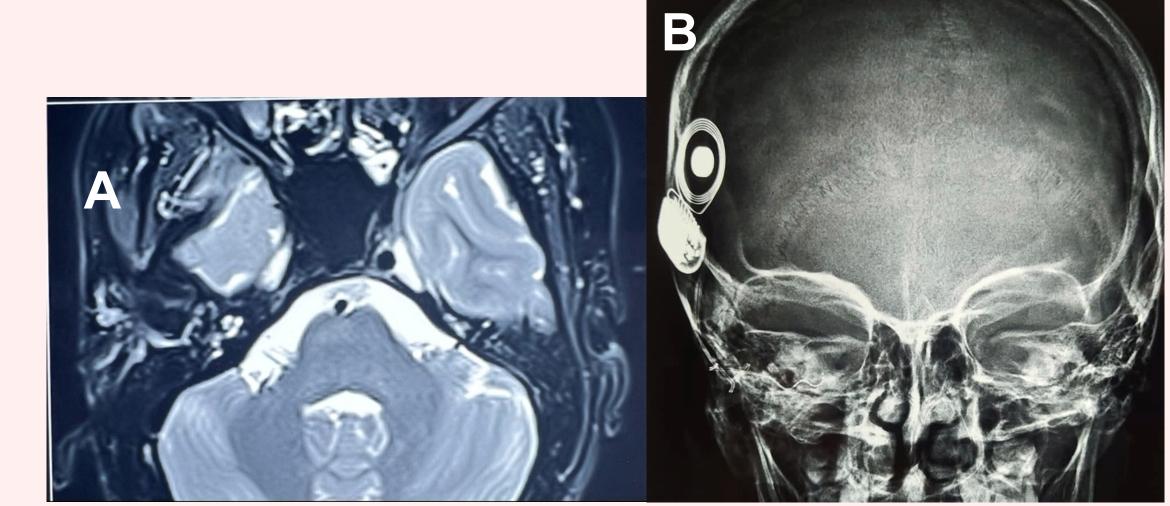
A) showing the MRI images of a post-meningitic patient with fibrosis of the right proximal basal turn who was successfully implanted. B) Postoperative Xray skull in transorbital view showing compressed electrode in situ in a case of cochlear fibrosis involving middle and apical turns.
